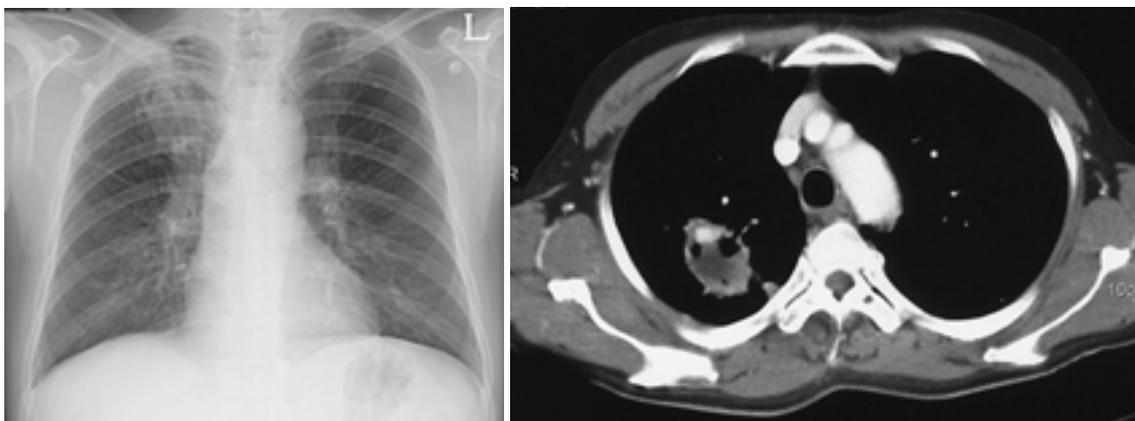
A. Plain film shows a mass with air-crescent sign, suggesting fungus ball at right upper lung.
